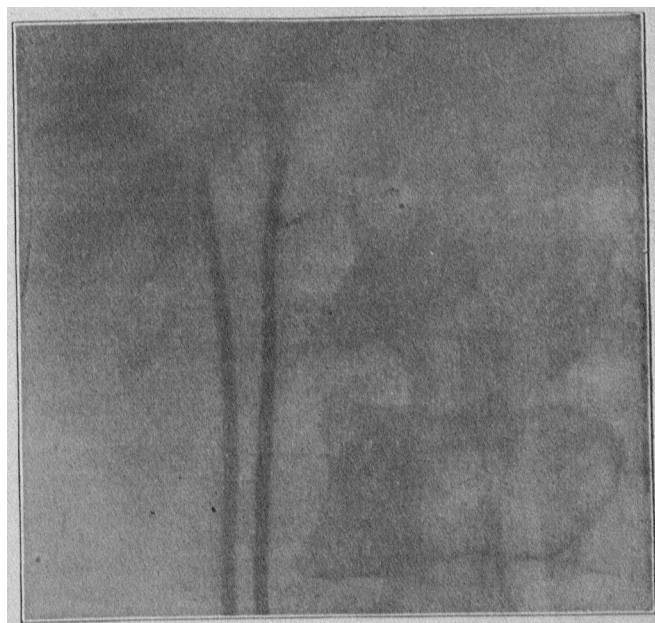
Radiograph with 20 per cent. argyrol (too weak), showing two right renal pelvises overlapping (non-communicating), and lead-impregnated catheters in double ureter.
